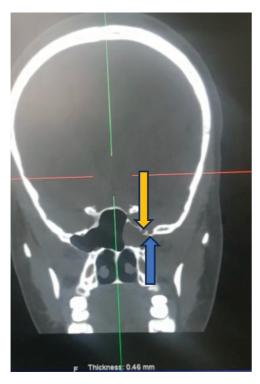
Coronal computed tomography (CT) scan showing opacified sphenoid sinus and dehiscence in the left lateral sphenoid sinus wall. The *blue arrow* depicts the foramen rotundum and the maxillary nerve. The *yellow arrow* shows the location of the dehiscence, medial to the foramen rotundum.
